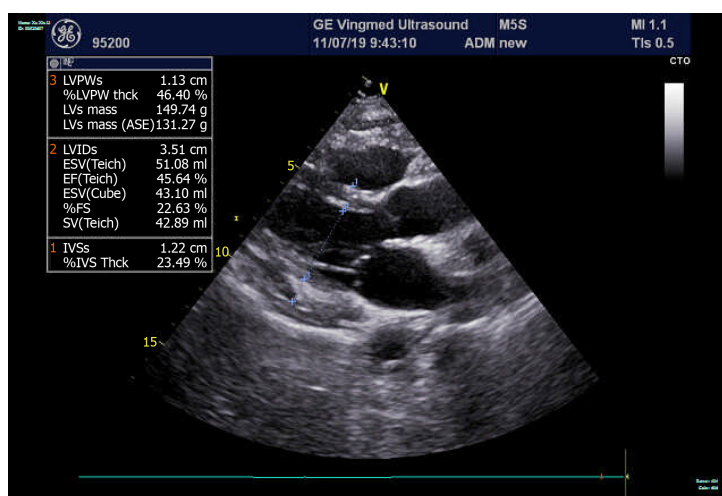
Echocardiogram. Echocardiogram pre-operation showed a normal left ventricular ejection fraction of 58% and normal cardiac chamber size with no structural abnormality of both ventricles. LVPWs: Left ventricular posterior wall systolic thickness; LVPW: Left ventricular posterior wall; LVs mass: Left ventricular end-systolic mass; LVIDs: Left ventricle internal diameter at end-systole; ESV: End-systolic volume; EF: Ejection fraction; FS: Fractional shortening; SV: Systolic volume; IVSs: Interventricular septum end-systolic thickness; IVS: Interventricular septum.
